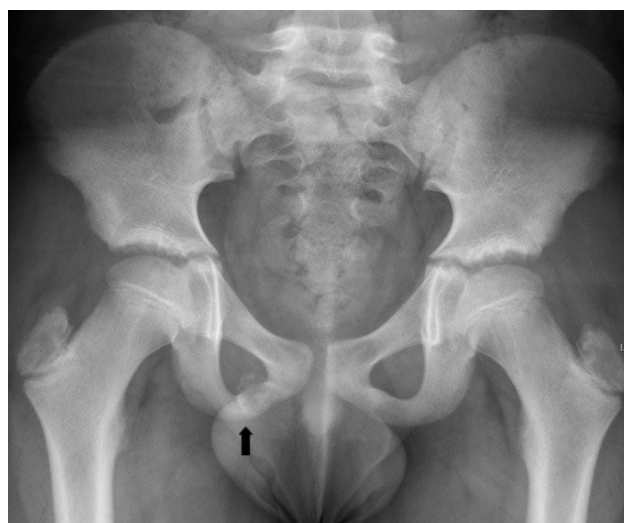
Pelvic radiograph. Asymmetry of the ischiopubic sychondroses, with identification on the right of an ovoid-shaped lesion (arrow), predominantly radiolucent, with mildly sclerotic margins and no evidence of periosteal reaction.
